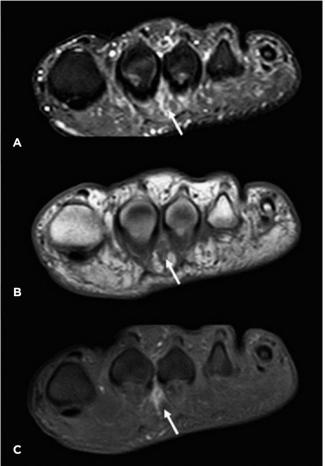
MRI sequences in a 51-year-old woman with pain in the plantar surface of the forefoot for ten days after a marathon. (A) Coronal fs T2-w of the forefoot shows enlargement and perivascular edema in the second intermetatarsal vein in the plane of the metatarsal neck (arrow), with obliteration of the adjacent fat planes. (B) Coronal T1-w sequence of the forefoot shows obliteration of the fat planes of the second interspace in the plane of the metatarsal neck (arrow). (C) Coronal postcontrast fs T1-w shows a filling defect in the contrast study (arrow) of the intermetatarsal vein of the second associated space and edema with contrast enhancement of the perivascular planes.
